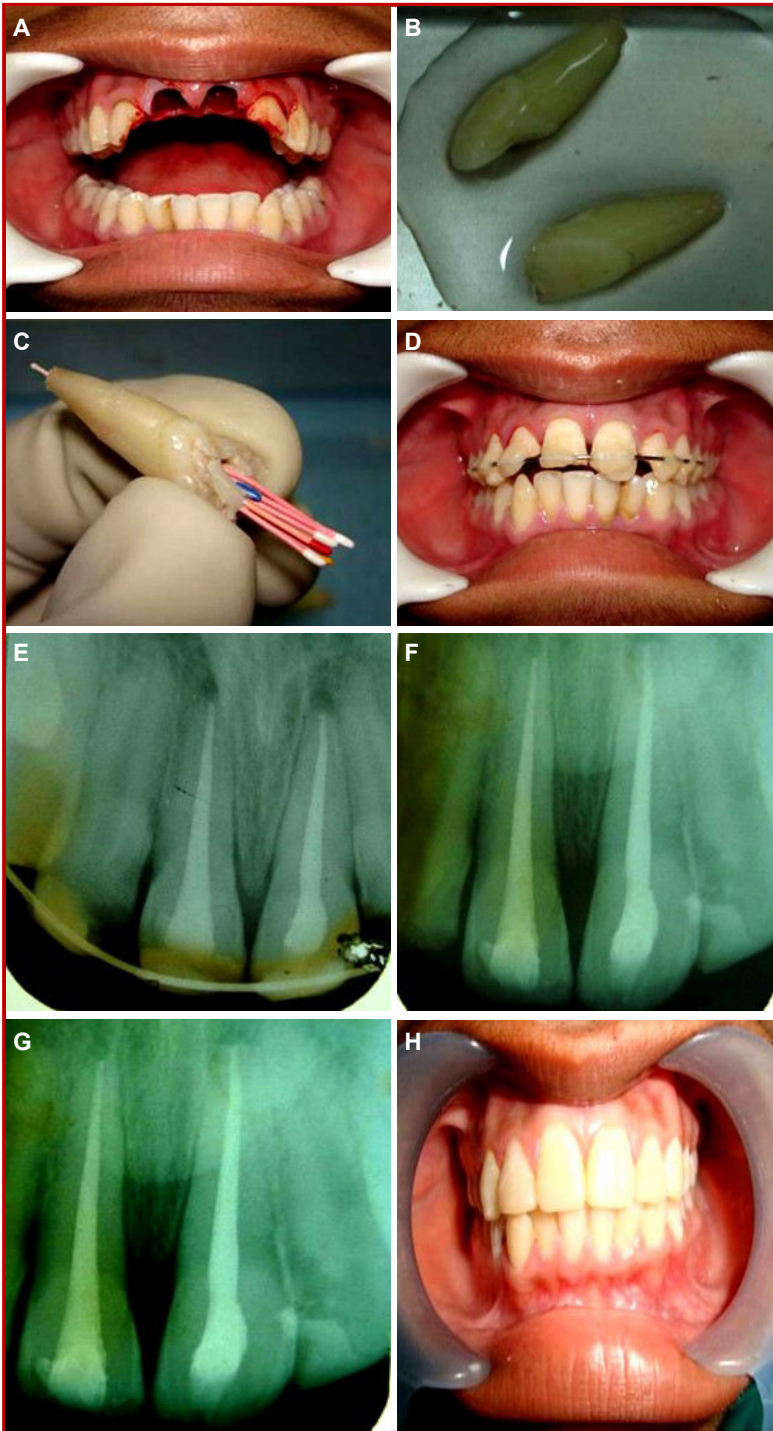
Absence of two central incisor teeth following accident (A), The avulsed teeth (B), Root canal filling (C), Functional splinting (D), Periapical image after replantation of teeth (E), Periapical image after 3 months (F), Periapical image after 6 months (G) and Photograph after 6 months (H)
